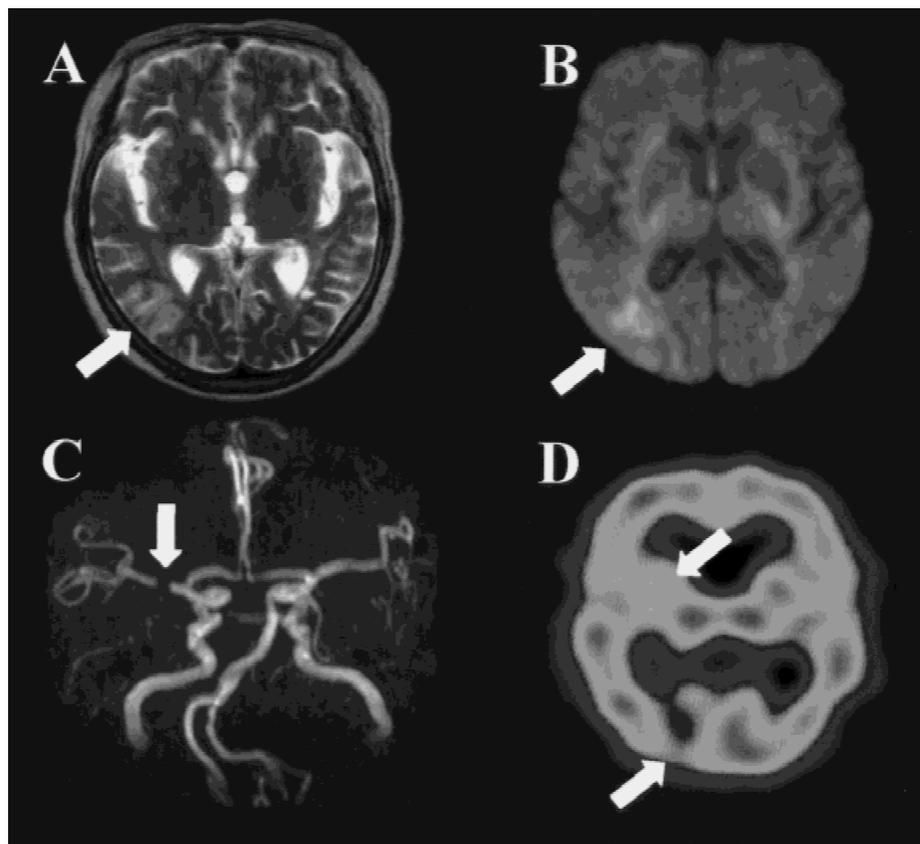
(A) T2-weighted and (B) diffusion magnetic resonance axial brain imaging studies show a high signal intensity lesion (arrows) at the right posterior parietal lobe corresponding to the posterior border zone. (C) Magnetic resonance cerebral angiography study shows nearly complete obstruction at the M1 portion of the right middle cerebral artery (arrows). The right basilar communicating artery is not visualized. (D) [^{99m}Tc]-HMPAO brain SPECT study shows decreased cerebral perfusion at the right striatum and posterior border zone (arrows).
